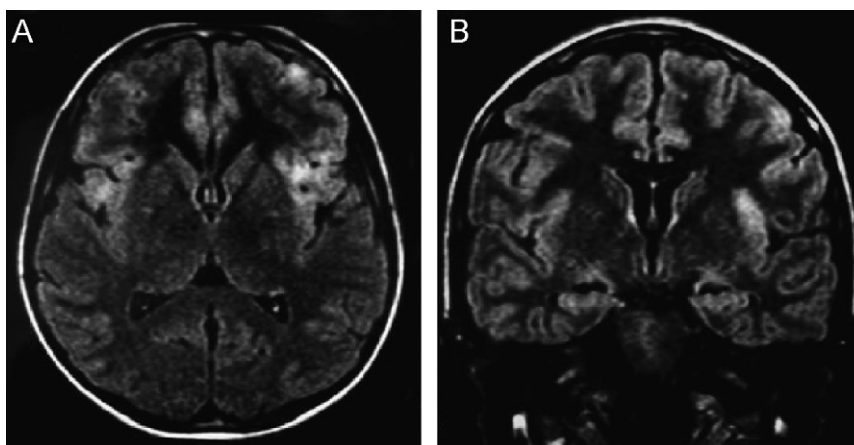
Axial (A) and coronal (B) MRI FLAIR sequences revealing multiple bilateral cortical high signal intensities predominantly in insular regions.
